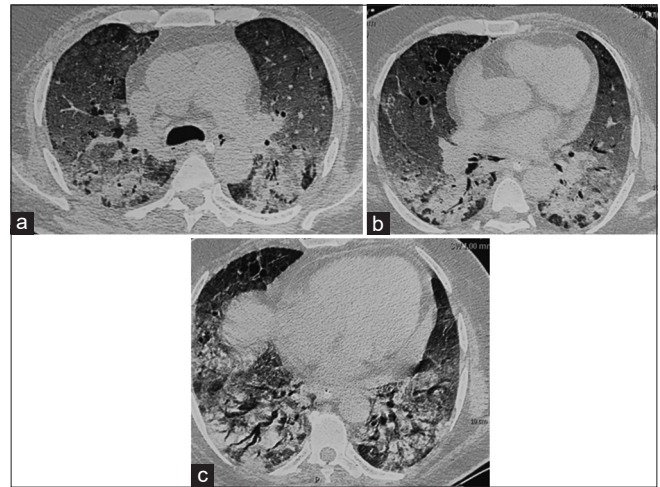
(a-c) A 52-year-old male, post-COVID pneumonia with new appearance of bilateral chest opacities on X-ray. An HRCT thorax was done with showed bilateral new appearance of diffuse ground-glass opacities, few borderline size mediastinal lymph nodes consistent with acute infection, superimposed on areas of architectural distortion, and traction bronchiectasis.
